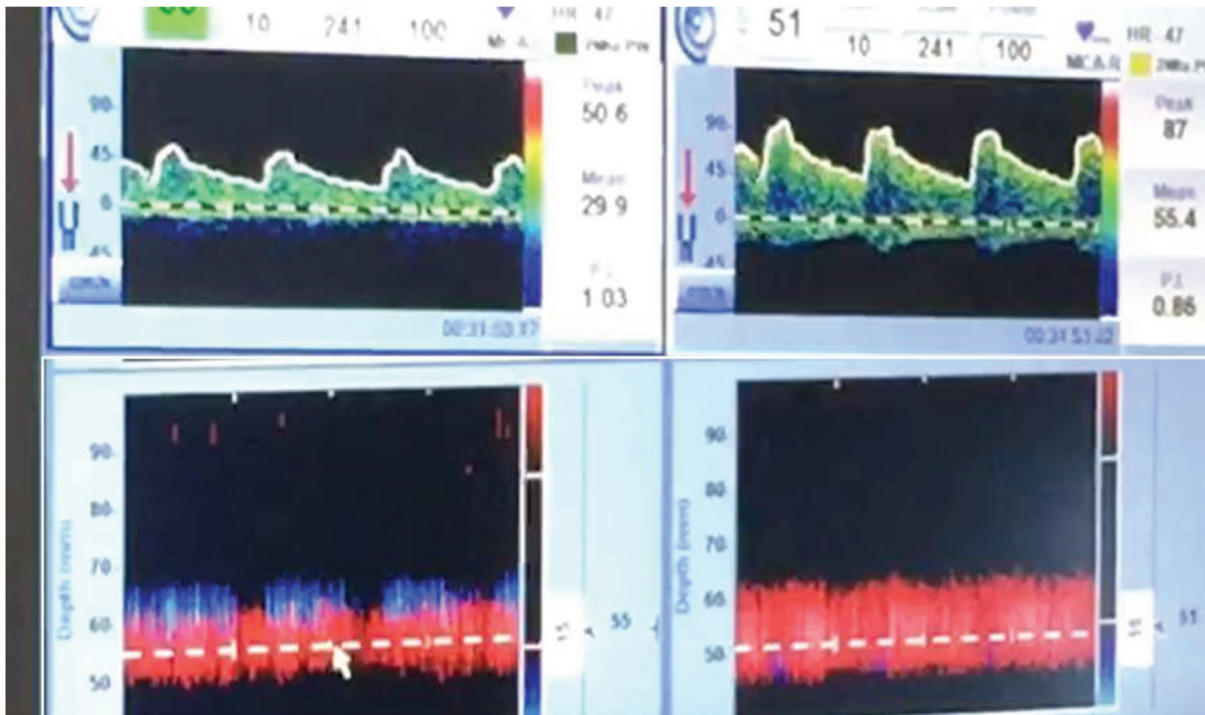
Transcranial Doppler of a patient with carotid stenosis who underwent CAS. Baseline MCA velocity (left) became almost double after 12 hours of CAS. Patient was actively managed with intensive BP control for 48 hours and was discharged when the velocities returned to baseline values.
